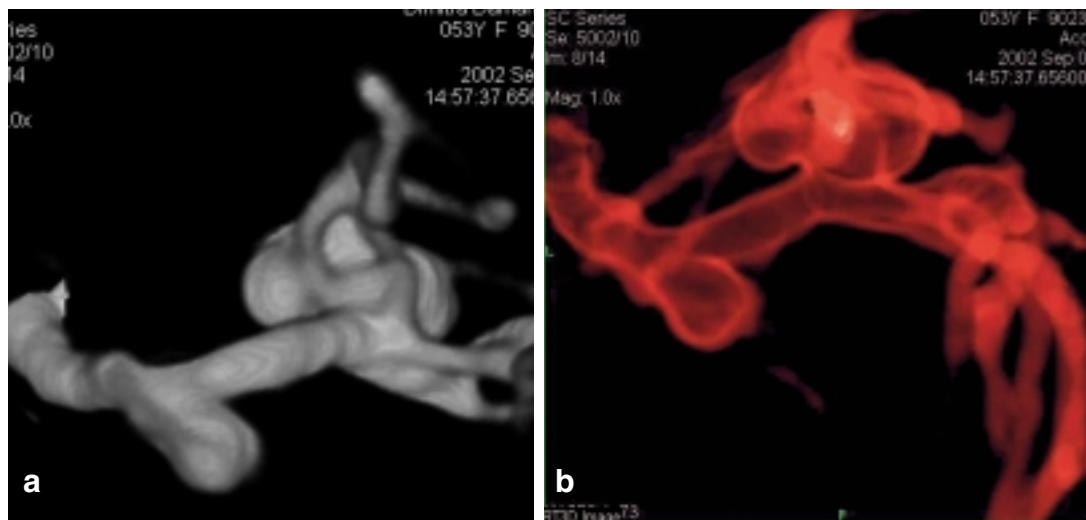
Volume rendering targeted CTA of two aneurysms arising from the internal carotid artery (a) and the middle cerebral artery bifurcation (b). The location, configuration, and relationship to the parent arteries and adjacent branches is well delineated. CTA with 30 ml contrast 400 mg I/ml
